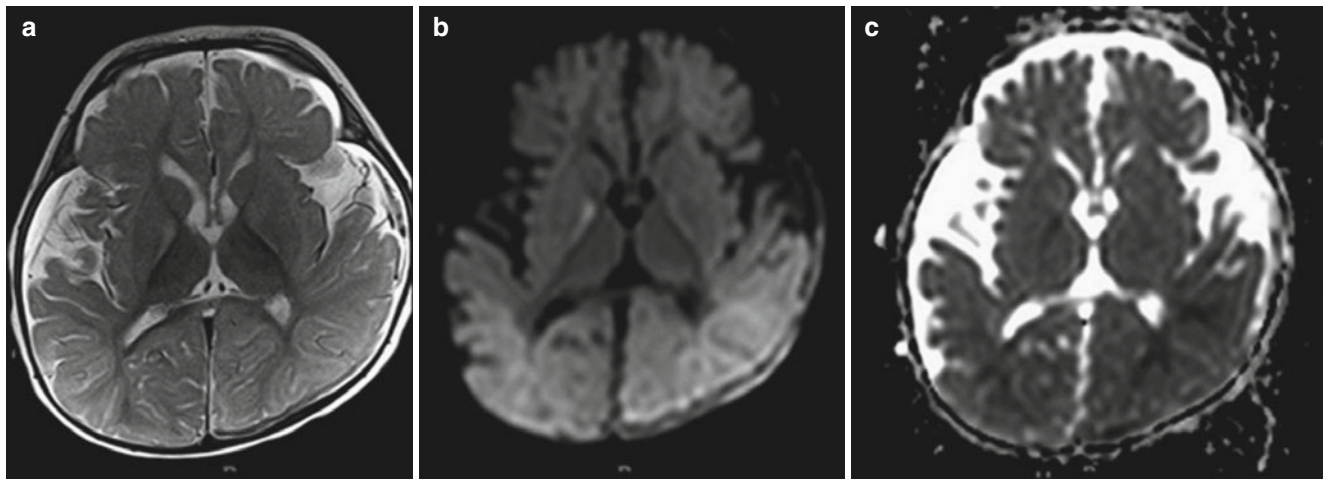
Axial magnetic resonance images of a young infant exposed to inflicted injury with resultant concomitant hypoxic-ischemic injury. Axial T2-weighted MR image (a) shows bilateral hemorrhages along the convexities and focal shear injury of the splenium. Additional T2 hyperintense signal in the bilateral medial segment of the globus pallidus and diffuse T2 hyperintensity in the bilateral parieto-occipital brain parenchyma and adjacent cortex in conjunction with reduced gray-white
